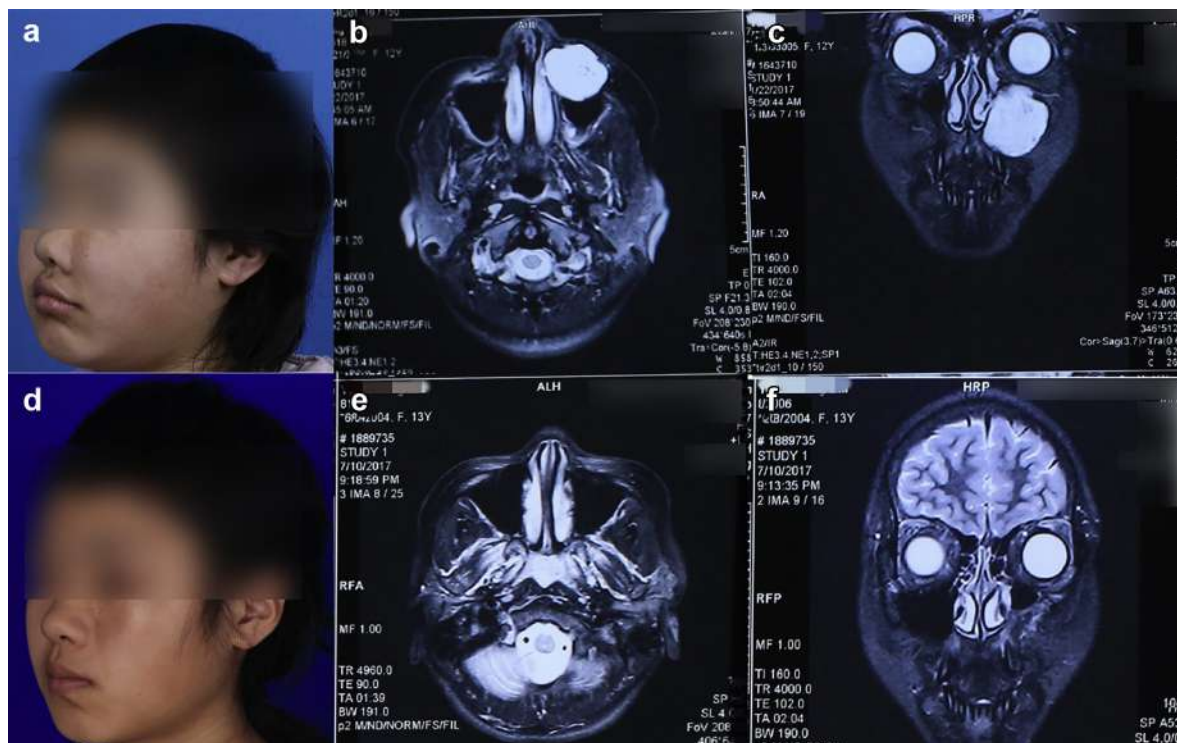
A 13-year-old girl with localized venous malformation (VM) of the face treated by bleomycin-polidocanol foam (BPF) sclerotherapy. a, Clinical appearance before treatment showing a mass on the left side of the face. b and c, Pretreatment T2-weighted magnetic resonance imaging (MRI) showing a hyperintense mass of the right facial region. d, After one session of BPF sclerotherapy, significant improvement of VM lesions was obtained. e and f, Post-treatment T2-weighted MRI 6 months after treatment showing complete resolution of VM lesions.
